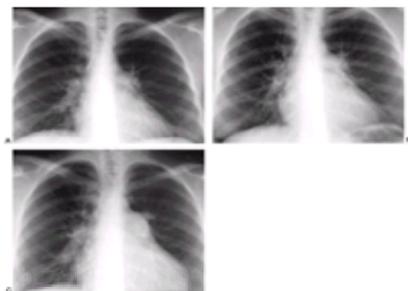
Progression of chest x-ray in a 34-year-old woman with a primary pulmonary hypertension-like syndrome associated with human immunodeficiency virus syndrome. A: Chest x-ray taken in 1991. B: Chest x-ray taken in 1992. C: Chest x-ray taken in 1994. Note the progressive dilation of the main pulmonary arteries and cardiac dilation over the years.
